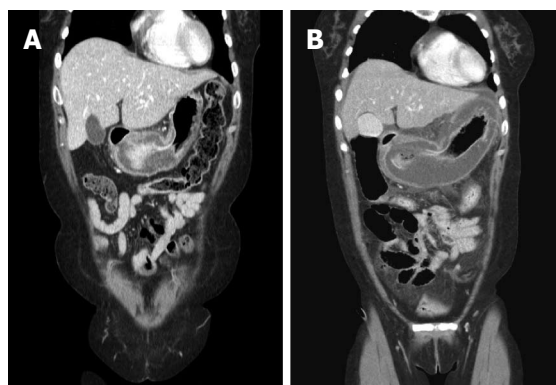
Thickening of the stomach wall was aggravated on abdominal computed tomography. The diameter of the thickened antrum wall increased from 1.7 to 4.0 cm over a 20 h period. A: A computed tomography (CT) reconstruction image taken at another hospital approximately 20 h earlier; B: An initial CT reconstruction image taken at our hospital.
